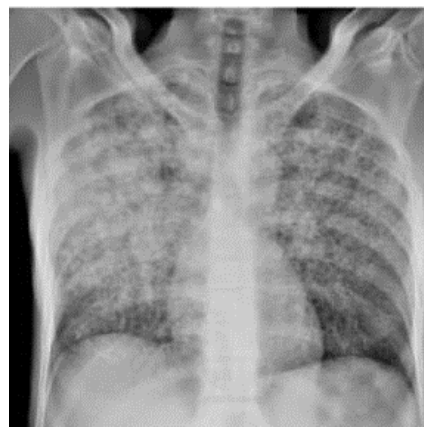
The chest X-ray, reticulonodular opacity and areas of consolidation in the mid and upper zones of the lung
